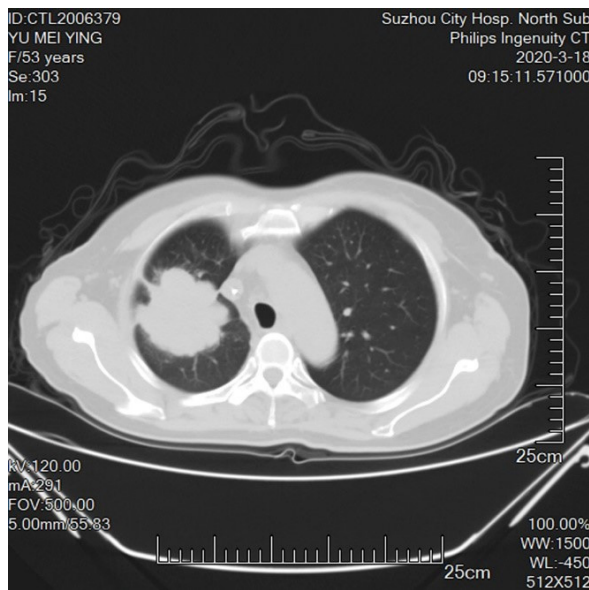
102 were nodular lesions which were indicated by CT.
